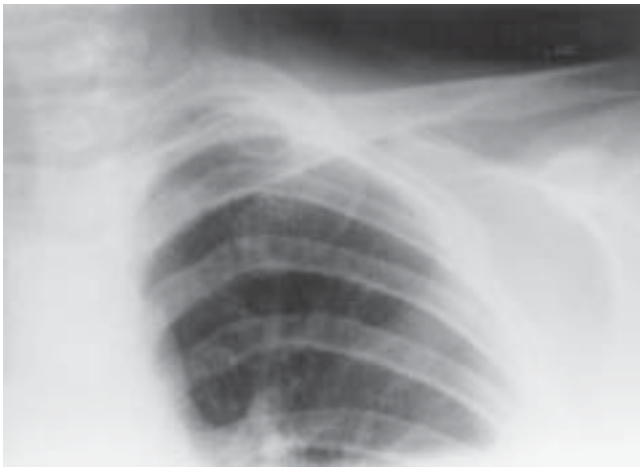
Anterior-posterior radiograph of shows a lucency of the superior medial left clavicle.
